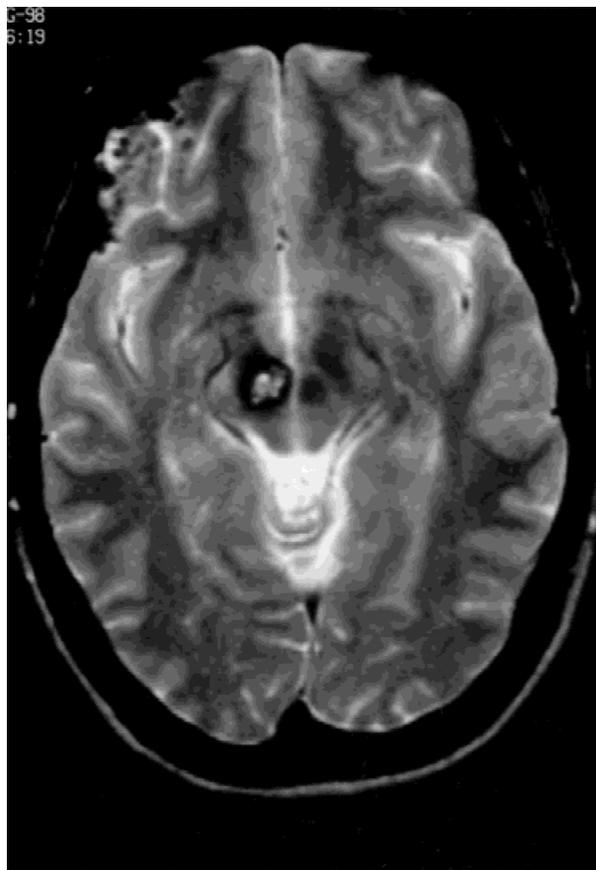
Brain MRI demonstrating low signal intensity lesion on T1 and high signal intensity lesion on T2, consistent with a cavernous hemangioma in the right anterior midbrain.
